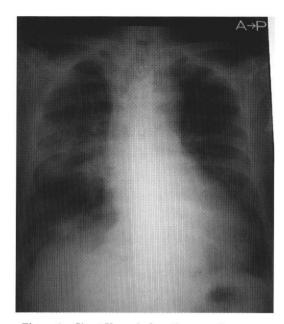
Chest X-ray before the second surgery
